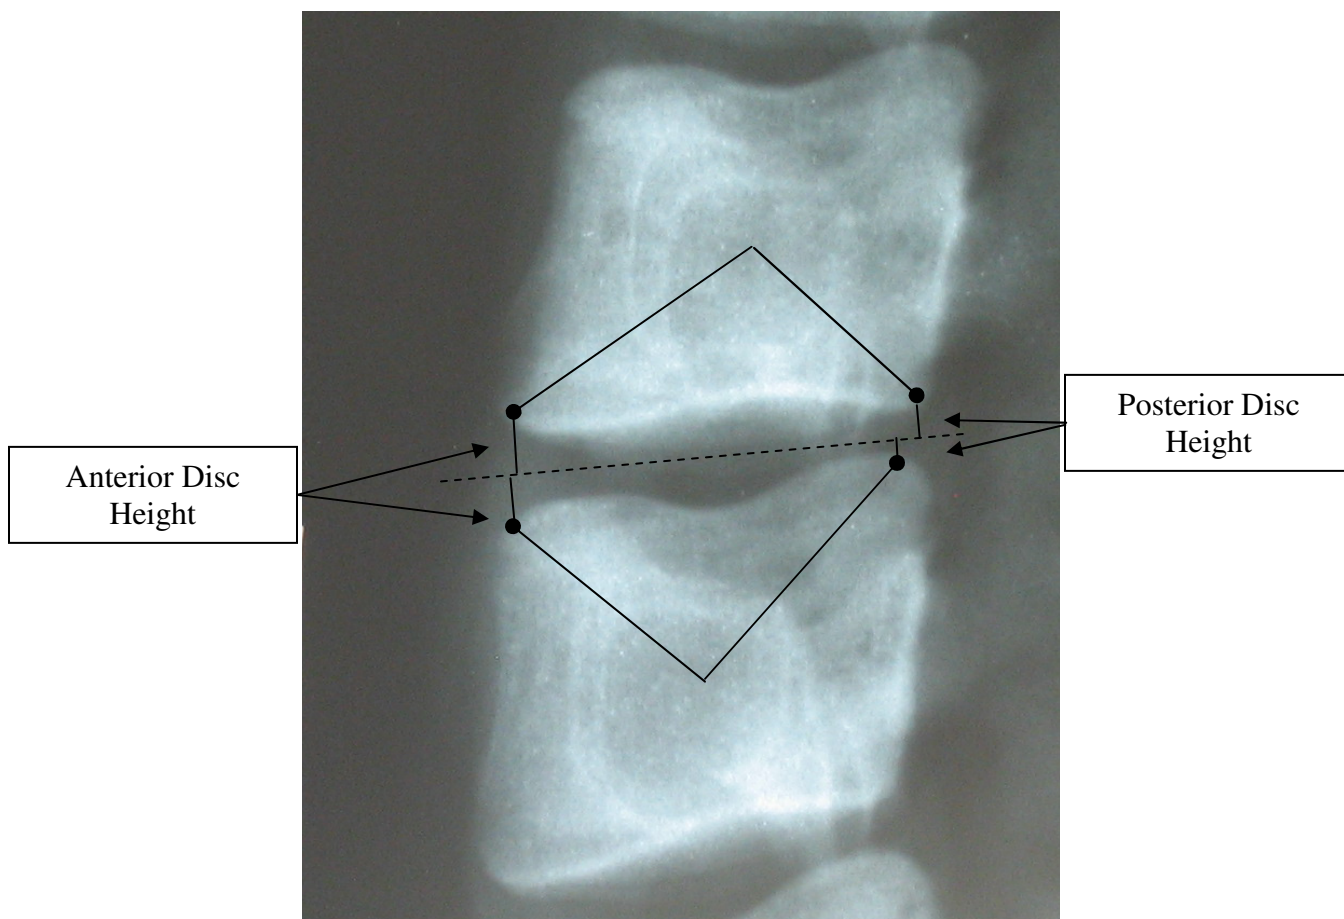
As per Wilke et al (2006) anterior disc height is calculated as the sum of the perpendicular distances from the anterior edges of the superior and inferior vertebral bodies (anterior black dots) to the midplane of the disc (dashed line). The edges of the vertebral bodies are identified as the points that are furthest from the center of the vertebral body. Posterior disc height is the sum of the distances from the posterior edges of the superior and inferior vertebral bodies (posterior black dots) to the midplane of the disc. Both in Wilke et al (2006) and in the current study the disc height was measured directly from the lateral x-ray images by each observer. Wilke et al (2006) expressed disc height as a percentage of the normal values reported by Frobin et al (1997). In the current study disc height loss was expressed as a percentage of the pre-test disc height (post-preload) and the anterior and posterior disc heights were averaged to give one figure for disc height loss.
